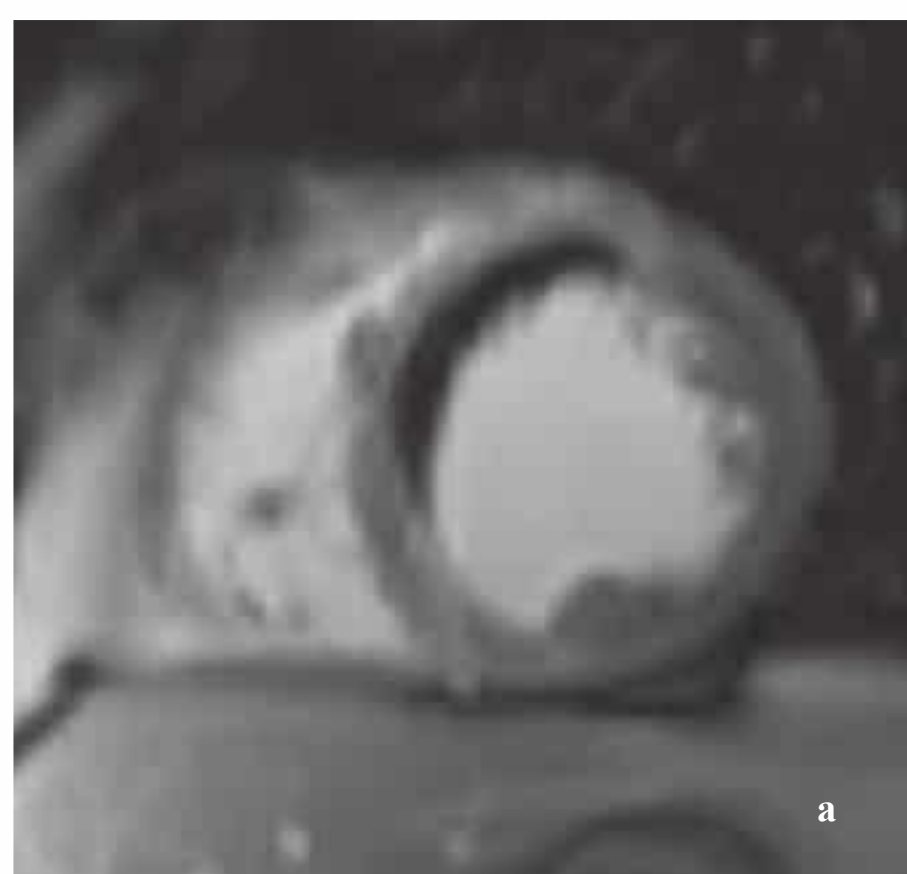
a–c Contrast-enhanced MRI in a patient with myocardial infarction and successful stent PTCA of the LAD.
